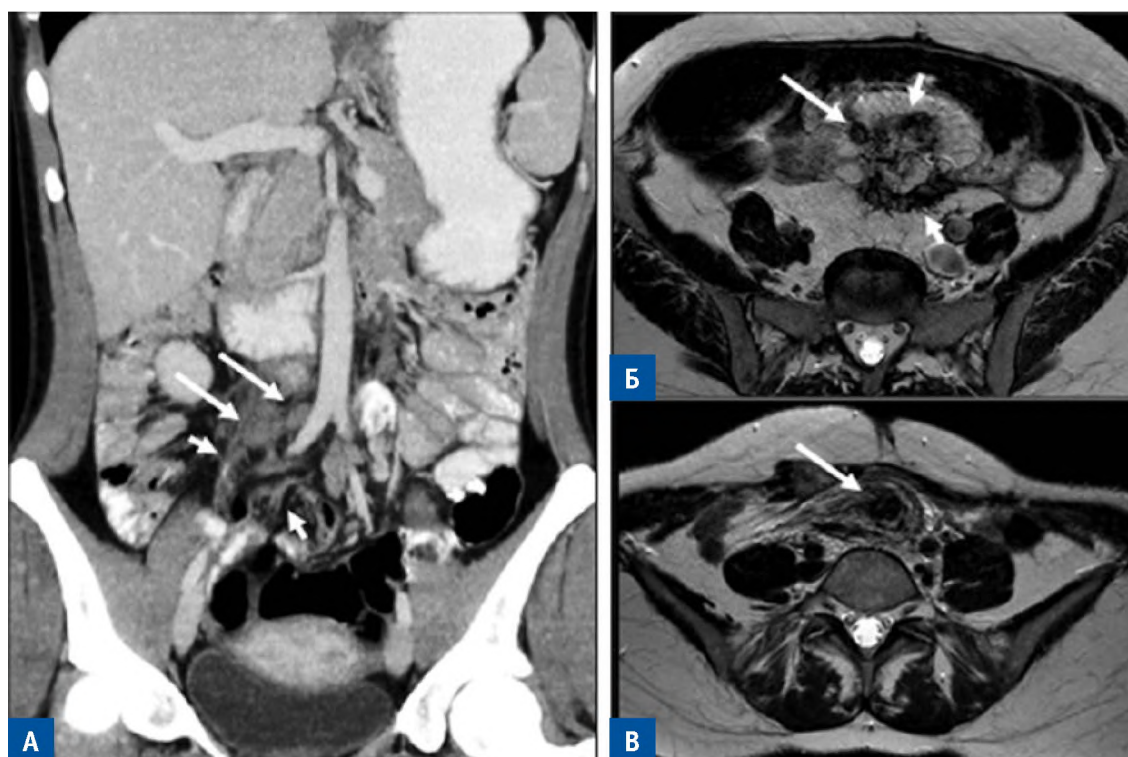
Combination of infiltrative and nodal form of desmoid-type fibromatosis of the small intestine mesentery. A — CT in the coronal projection of patient Sh., 26 years old; infiltrative (short arrows) and nodal (long arrows) DF components. B, B — MRI in the axial projection, T2-WI; Б — tomogram of patient S., 47 years old; a mass up to 1 cm (long arrow) against the background of diffuse infiltration of the mesentery involving the loop of the small intestine (short arrows); Б — tomogram of patient X, 37 years old; a hypointense mass up to 1.5 cm against the background of diffuse infiltration of the root of the small intestine mesentery
